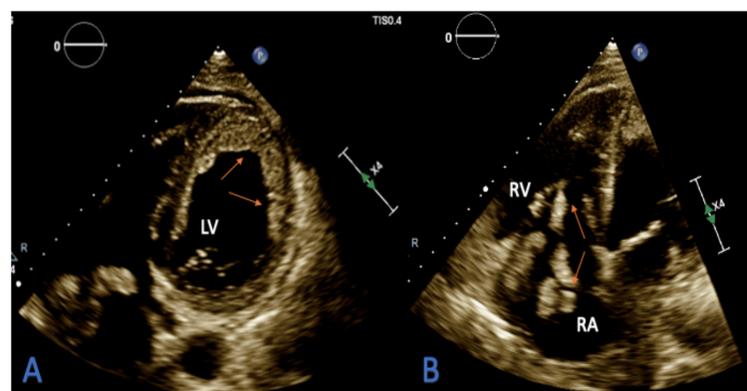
Transthoracic echocardiography (TTE) showing; A: An extensive mural thrombus (arrows) seen along all walls of the left ventricle (LV). B: Mobile right atrial (RA) thrombus (arrows) extending across the tricuspid valve and extending into the right ventricle (RV).
